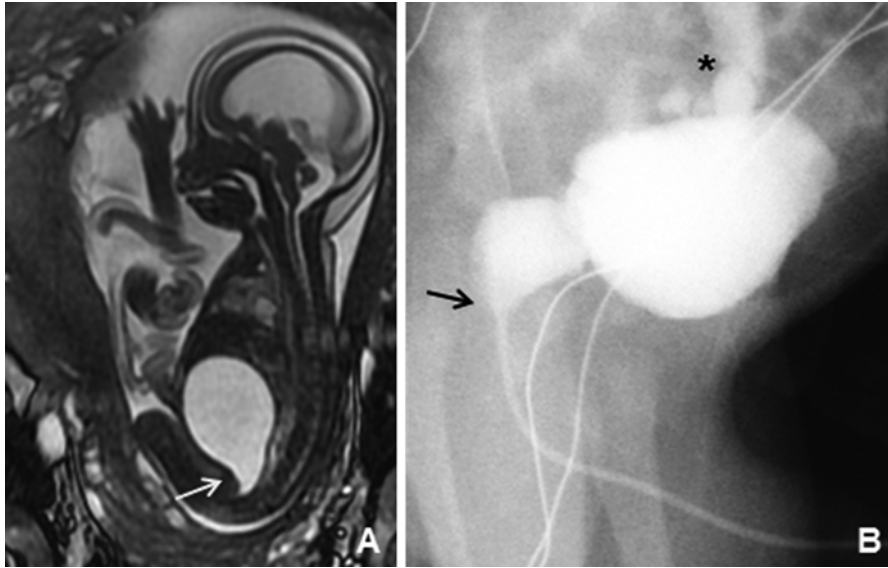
MRI and VCUG showing PUV. (a) This prenatal MRI demonstrates a markedly distended bladder which is bright on T2-weighted imaging and a classic “keyhole” sign, as demonstrated by the *arrow*. (b) On postnatal VCUG, the posterior urethra is dilated with a distinct transition point at the area of the valve, indicated by the *arrow*. High grade reflux is also demonstrated (*asterisk*)
